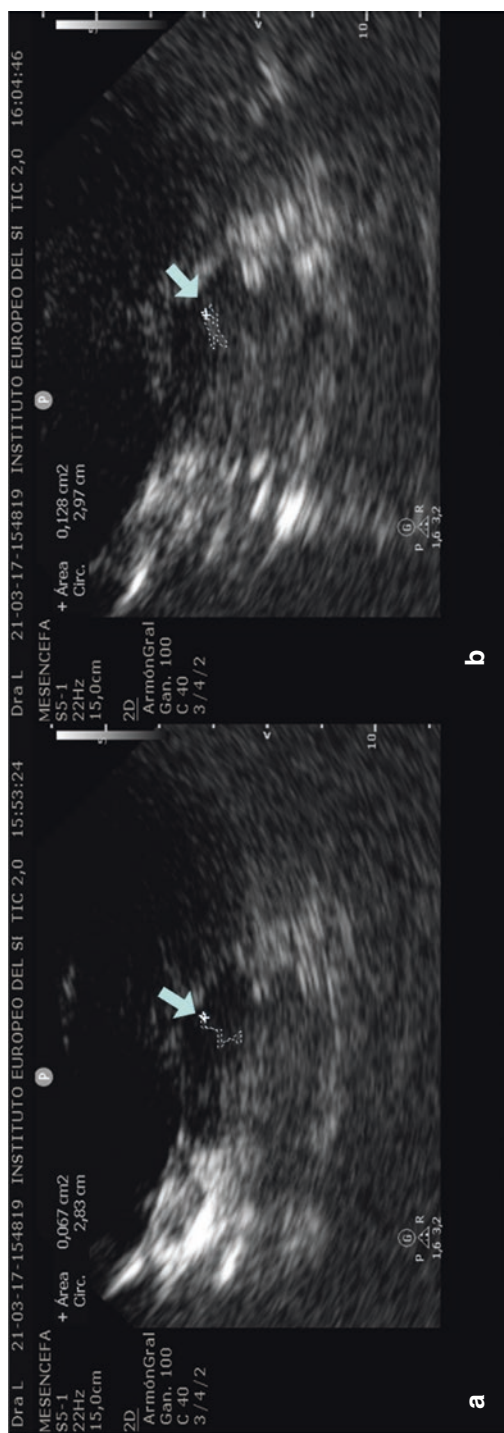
The midbrain is observed through transcranial ultrasound, the substantia nigra is measured on the left side (a) with an area of 0.067 cm² and on the right side (b) with an area of 0.128 cm². SN is pointed out in both sizes with blue arrows. The result confirms hypoechogenicity of the substantia nigra due to low brain iron deposits
